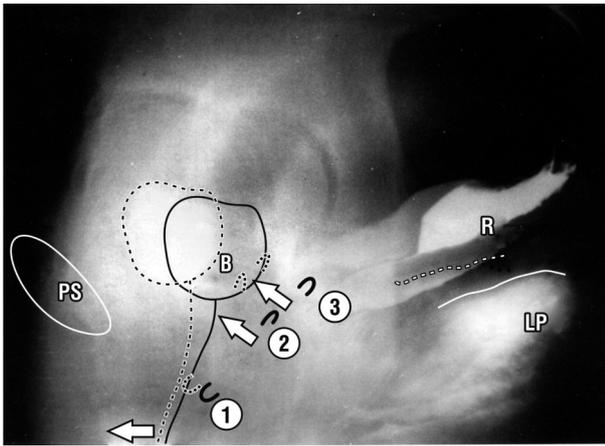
Squeezing. ‘Kegel Exercise’. Standing lateral xray, the squeezing film (broken lines) is superimposed on the resting film (unbroken lines). Vascular clips have been applied to the anterior vaginal wall: ‘1’ to midurethra; ‘2’ to bladder neck; ‘3’ to bladder base. The unbroken lines represent the resting position and the broken lines the squeezing position. The muscle movements during ‘squeezing’ elevate vagina, bladder ‘B’, rectum ‘R’ and levator plate ‘LP’ upwards and forwards. Note the difference with the movements in figure 2. Because ‘squeezing’ is not the natural mechanism, it must be learnt (Kegel 1948).
